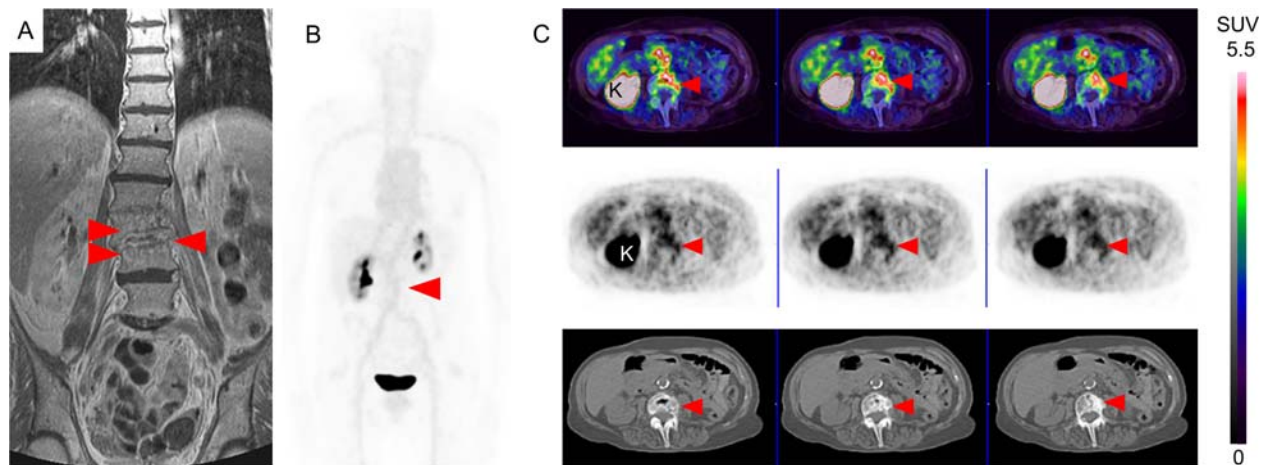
Representative MRI and ^{68}Ga -NOTA-UBI-PET-CT imaging in a patient with suspected spinal infection (spondylodiscitis). (A) Coronal T1 weighted MRI image (fat suppression), (B) whole-body MIP-PET image, and (C) sequential transaxial fused PET-CT (*top*), PET (*middle*) and CT (*bottom*) images showing focal increased uptake in the intervertebral region of L3-L4 corresponding to the abnormal findings on MRI. K=kidney.
